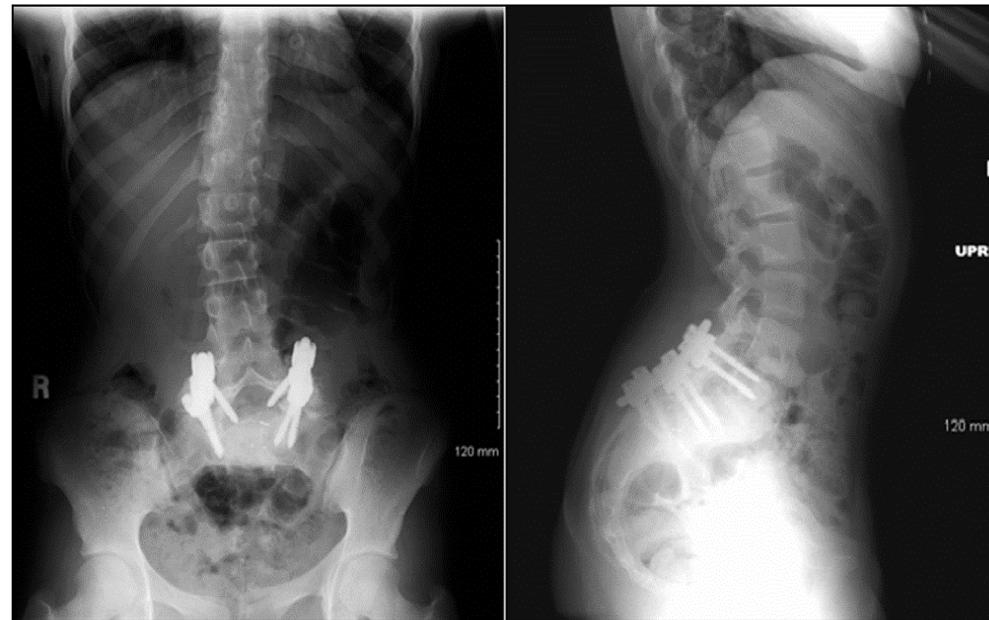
Plain film X-rays revealed scoliosis, mild L5 subluxation, and L4-S1 pedicle screws and vertical bars without additional horizontal bars.
